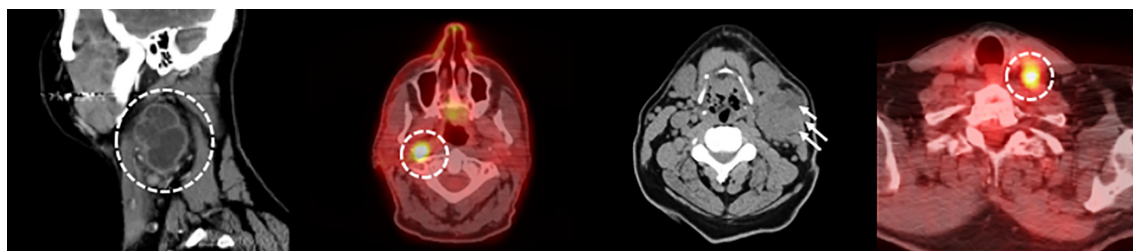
Examples of radiographic characteristics evaluated. From left to right: matted lymphadenopathy, retropharyngeal lymphadenopathy, overt radiographic extracapsular extension, and low-neck lymphadenopathy [Color figure can be viewed at wileyonlinelibrary.com]
